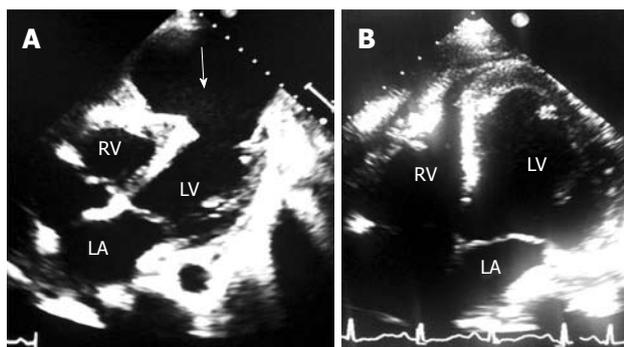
Echocardiography in apical 4 chamber view shows: A: Large left ventricle (LV) apical pseudoaneurysm as marked by a white arrow, measuring 60 mm × 90 mm, with a 30 mm neck; B: Post surgery, the well-delineated LV outline with complete removal of LV pseudoaneurysm. RV: Right ventricle; LA: Left atrium.
